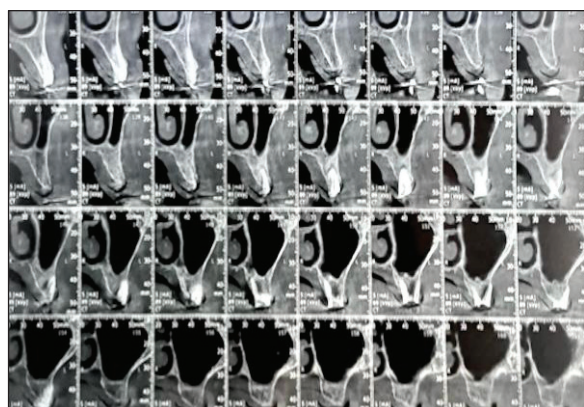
Pre-operative CBCT showing the coronal sections.
